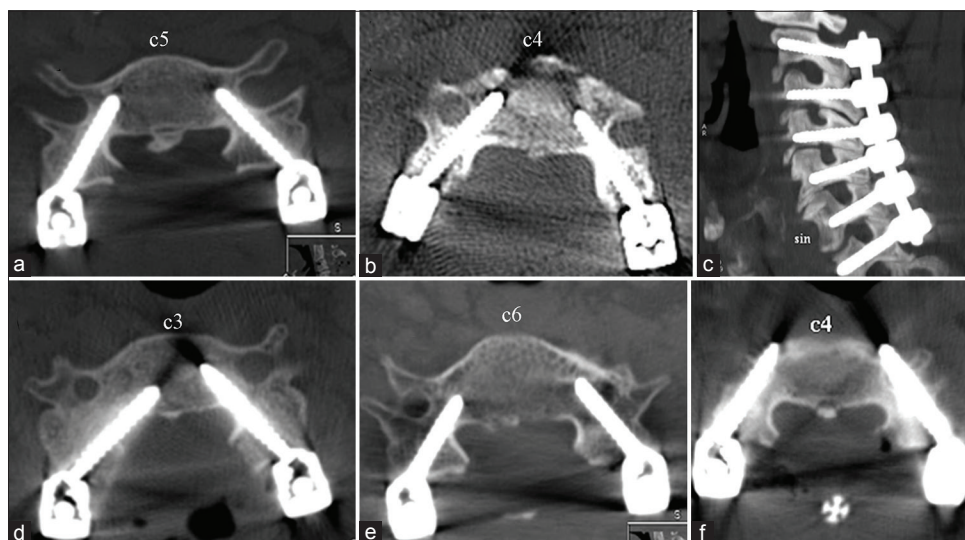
Position of the subaxial cervical pedicle screw on the postoperative computed tomography in the clinical application on six patients: (a-c) Satisfactory position, (d and e) permissible position, (f) unacceptable position
